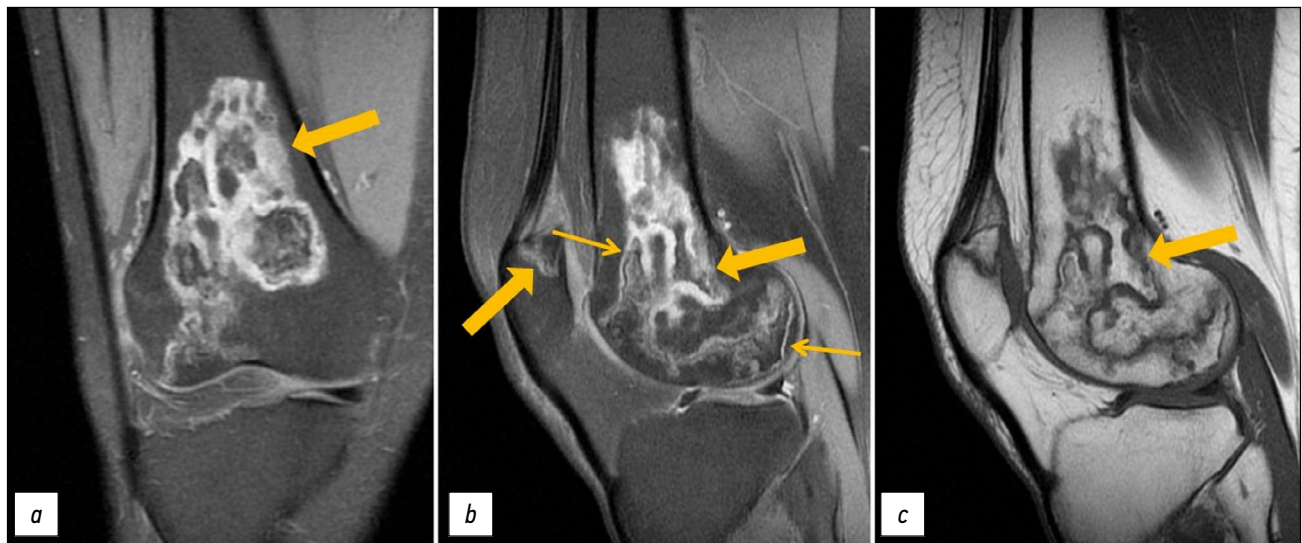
Follow-up MRI of the right knee joint: PDWI with fat suppression in the coronal (a) and sagittal (b) plane and T1WI in the sagittal plane (c). Thick arrows indicate areas of bone marrow edema in the form of a heterogeneous, irregularly shaped (“geographic”) MRI signal of femoral condyles and patella; thin arrows indicate the “double line” sign in the form of internal hyperintense (granulation tissue) and external hypointense (osteosclerosis) lines on PDWI.
